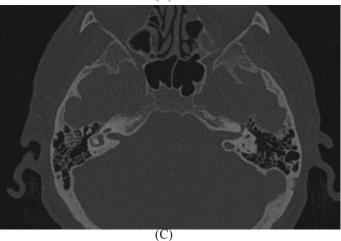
High resolution CT images, bone window, (A) axial image showing JBD at the level of the basal turn of the cochlea (A), eroding the posterior lip of the porus of the IAC (B), and posterior to the IAC at the level of the common crus (C). JBD: jugular bulb diverticulum. IAC: internal auditory canal.
